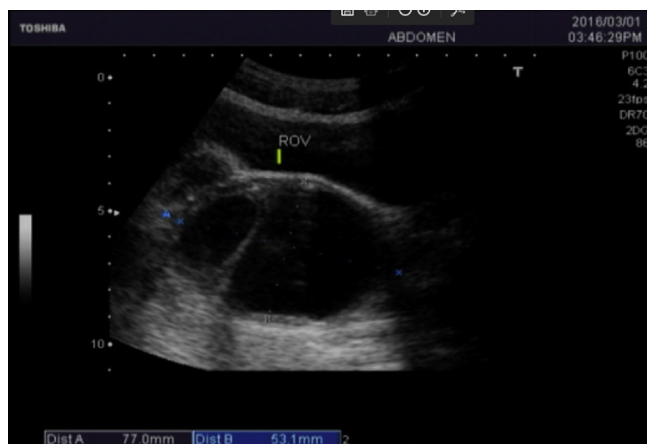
Ultrasonography showed a 7.7 cm × 5.3 cm lobulated cyst with clear echolucent content at right adnexa.
